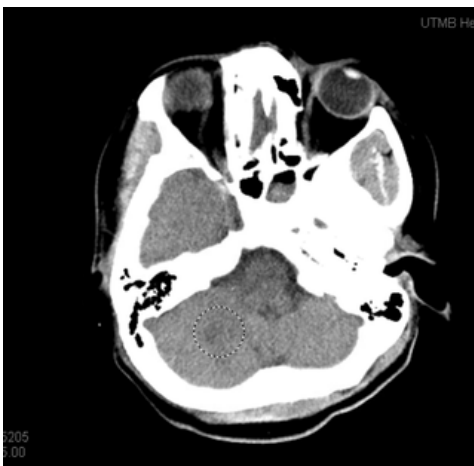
Head CT without contrast with occipital lobe hypodensity.
